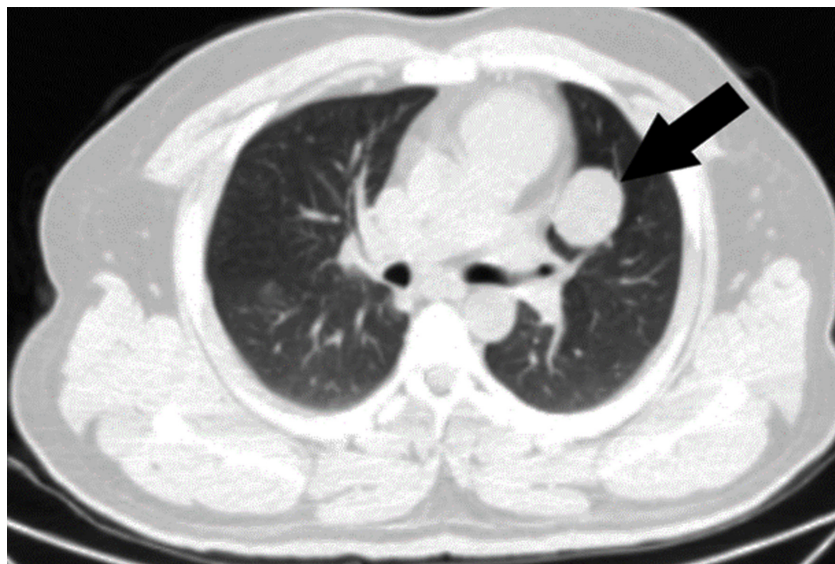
Chest CT shows a 4 cm lesion located at the anterior segment of the left upper lobe.
